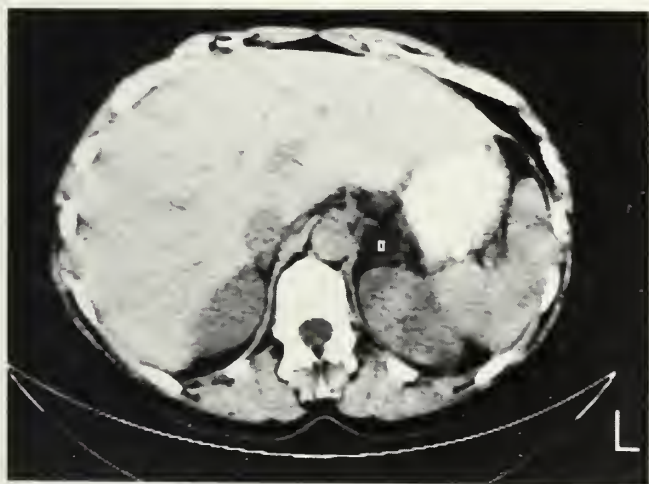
Non-contrast CT scan (5 mm thick) of the adrenal glands
